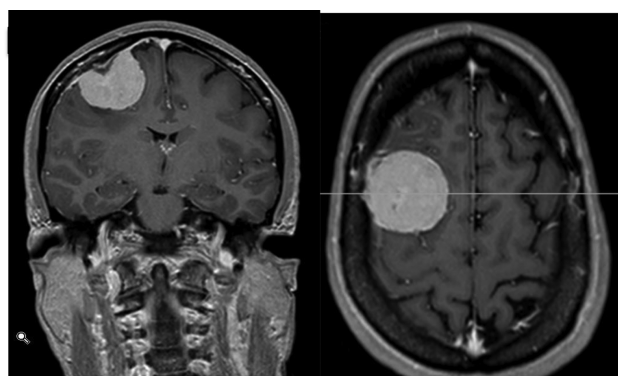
T1-weighted coronal (a) and axial (b) MRI with gadolinium administration showing a well-defined extra-axial lesion with an homogeneous enhancement and a contiguous dural enhancement (dural tail). A subtle CSF cleft is also visible between the lesion and the cerebral surface. These radiologic findings are typical for a convexitary meningioma.
